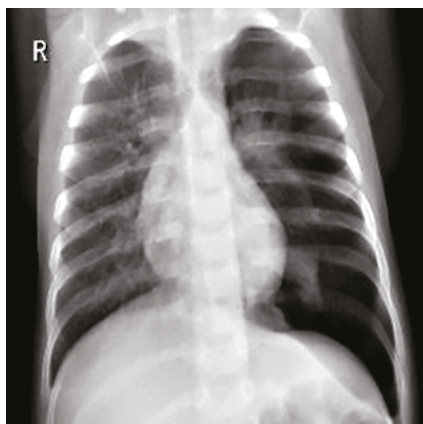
Sample X-ray image of pneumonia [18]
